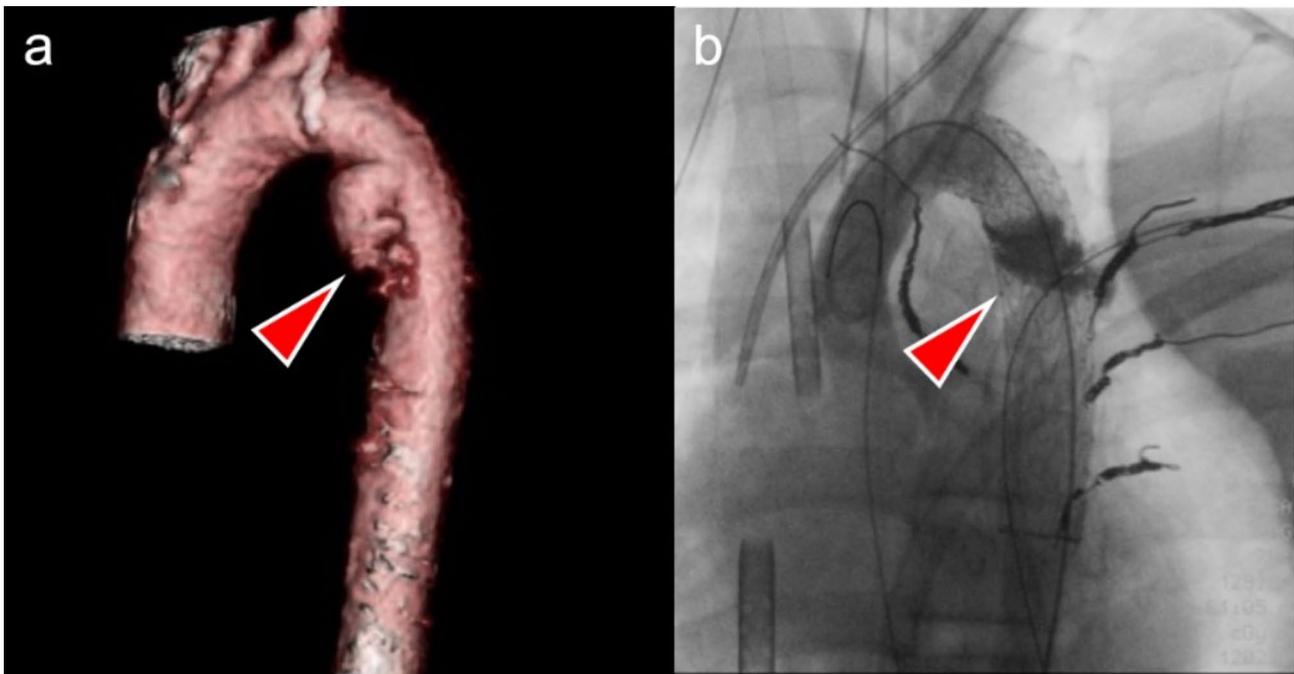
Location of pseudoaneurysm. The pseudoaneurysm was situated 8 mm distal to the left subclavian artery (a). Postoperative radiography showed that the pseudoaneurysm was filled with NBCA and Lipiodol (b)
